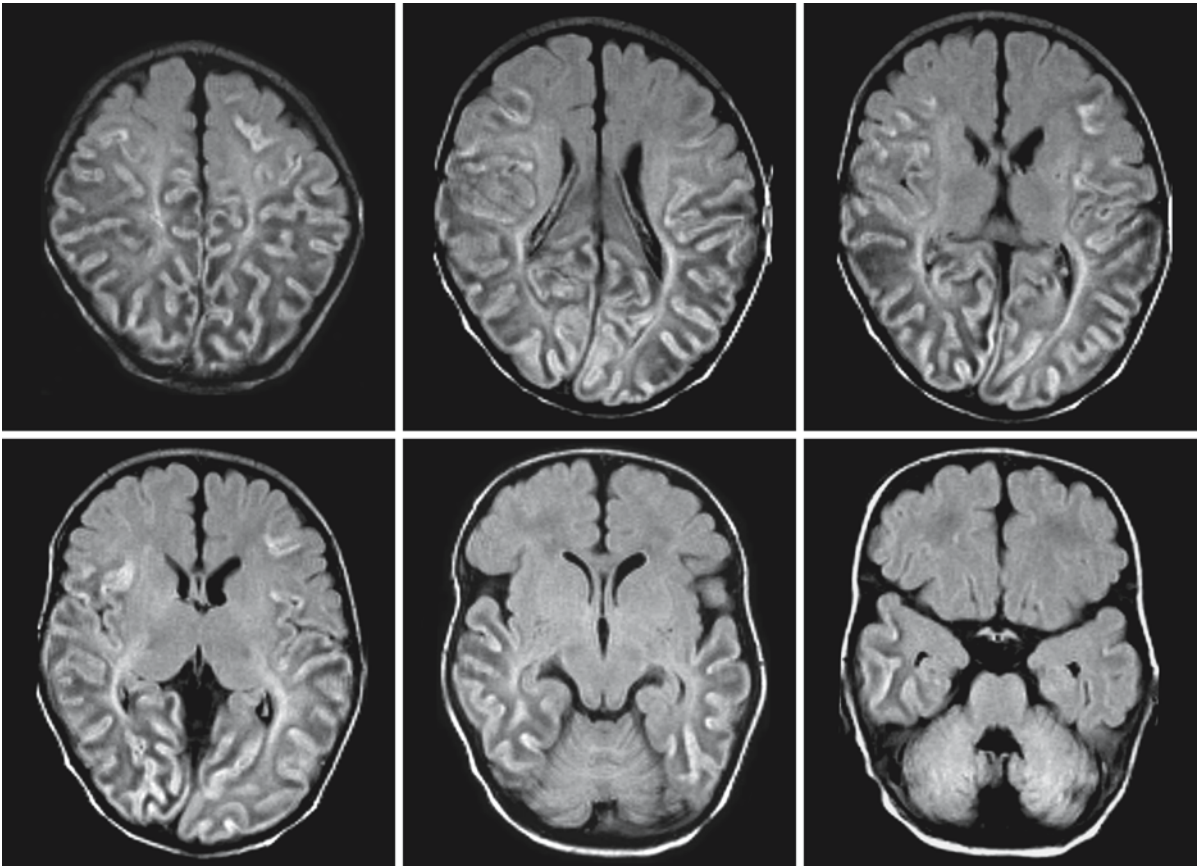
This series of FLAIR images, obtained at 21 days in the same boy, confirm the extensive cortical involvement. Only the most anterior part of the frontal cortex seems spared.
